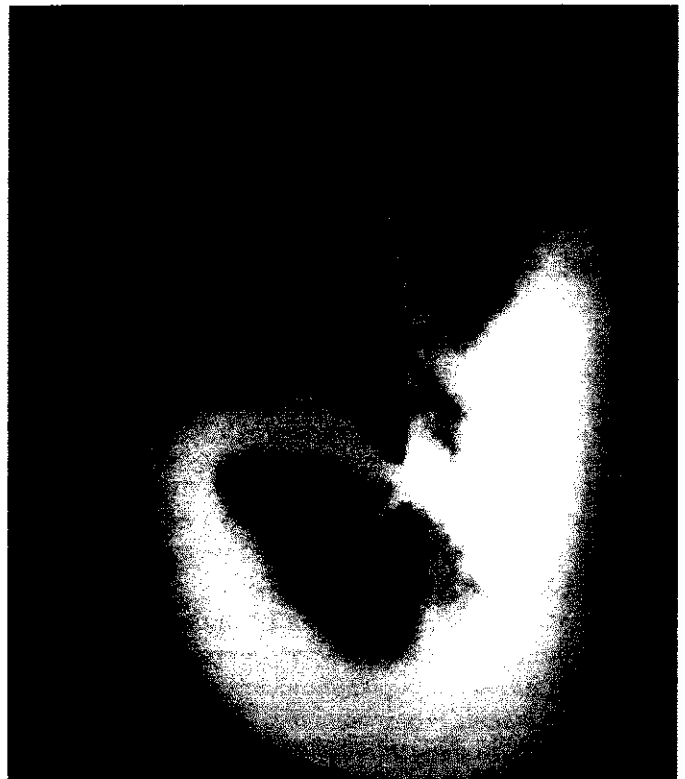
Barium x-ray showing a filling defect by trichobezoar in stomach
